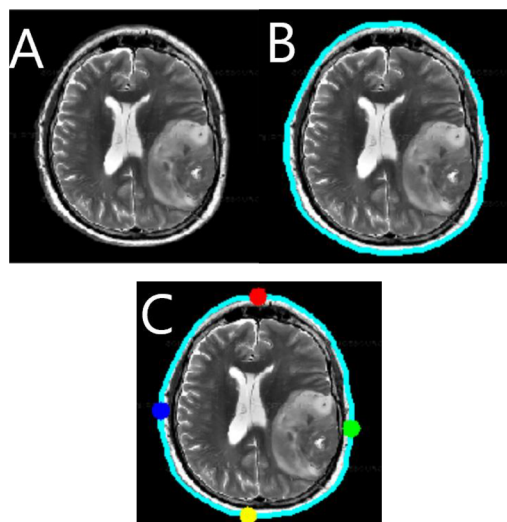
Given an MRI image (A), a preprocessing phase must be applied to extract the largest contour representing the border of the skull (B) and the four symmetrical extreme points that will be used to crop the image (C). (Own work).
